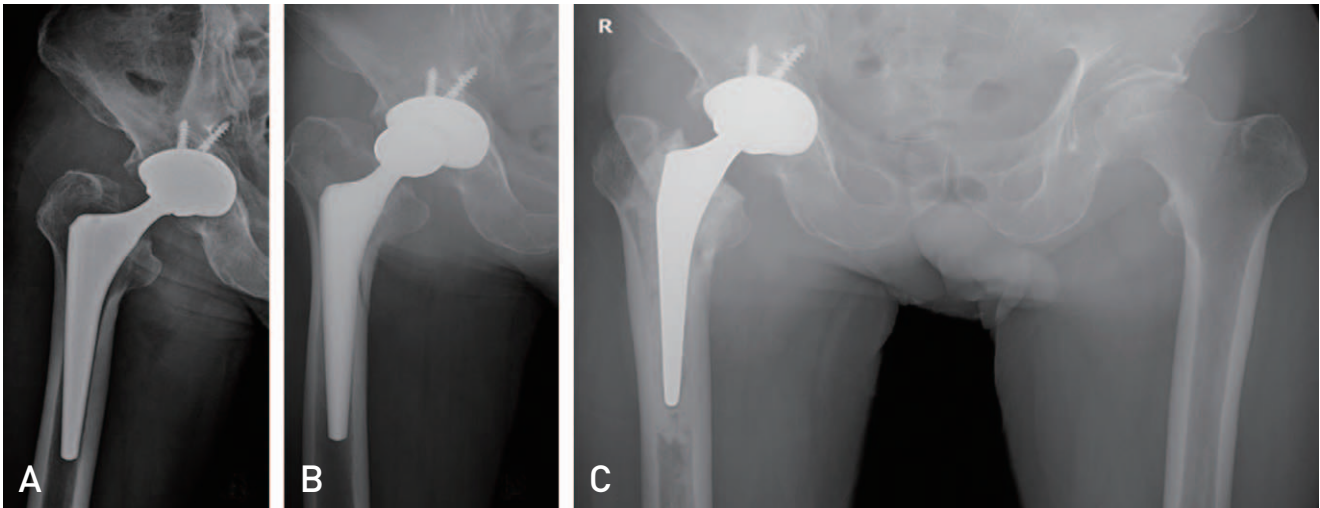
A 72-year-old male who underwent total hip arthroplasty using a tapered wedge cementless femoral stem in another hospital. (A) Immediate postoperative radiograph. (B) Three-month postoperative radiograph. Compared with the immediate postoperative radiograph, the fracture line was observed below the lesser trochanter with stem subsidence and head subluxation. (C) One-year post-revisional radiograph after revision using a cemented femoral stem.
